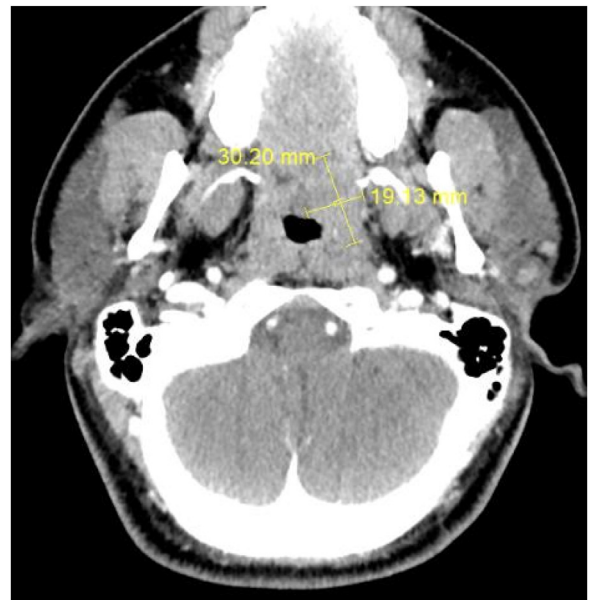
Axial CT scan with an inhomogeneous solid tumor of the left soft palate 3 on 2 cm.
